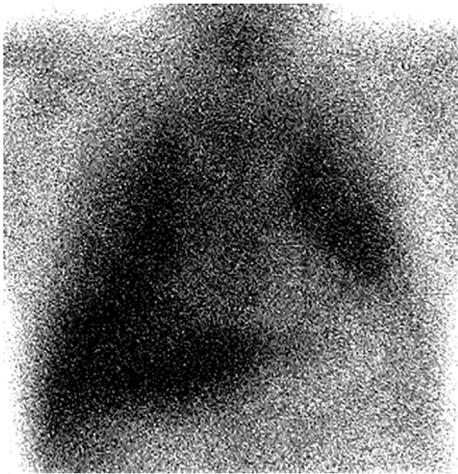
The negative heart sign on ^{67}Ga scintigraphy. The negative heart sign, as shown here, is seen when the amount of gallium taken up by the lungs is greater than the amount of gallium circulating in the blood, and therefore in the heart. This is a robust indication of diffuse pulmonary inflammation.
